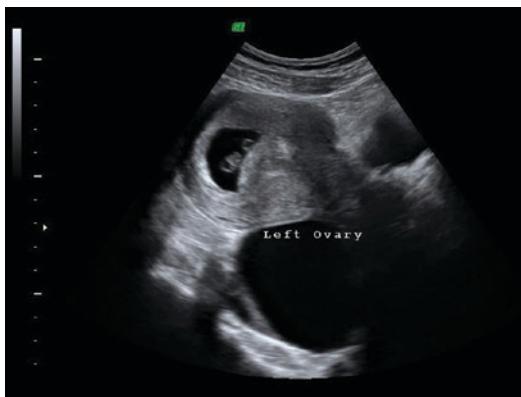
Ultrasonographic image showing a left ovarian cyst in a pregnant woman at 9 weeks
